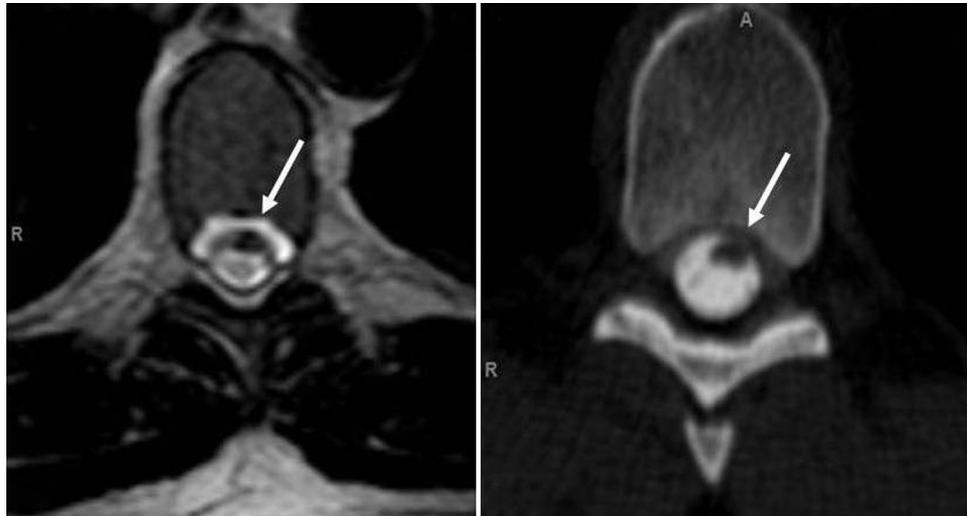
(Left) Magnetic resonance imaging T2 axial and (right) axial computed tomography myelogram images of the thoracic spine with arrows showing ventrally displaced cord and extradural cerebrospinal fluid/contrast, respectively.
